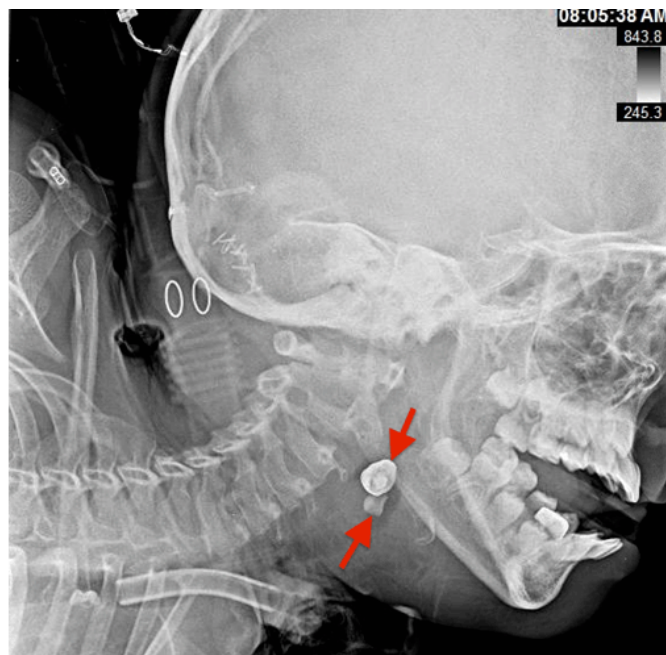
An eight-year-old boy with two radiopaque densities incidentally found on modified barium swallow study. Findings: Two radiopaque objects (red arrows) at the level of the hypopharynx near the cervical esophagus. Technique: Lateral skull plain radiograph performed eight months prior to discovery of foreign bodies on modified barium swallow study.
